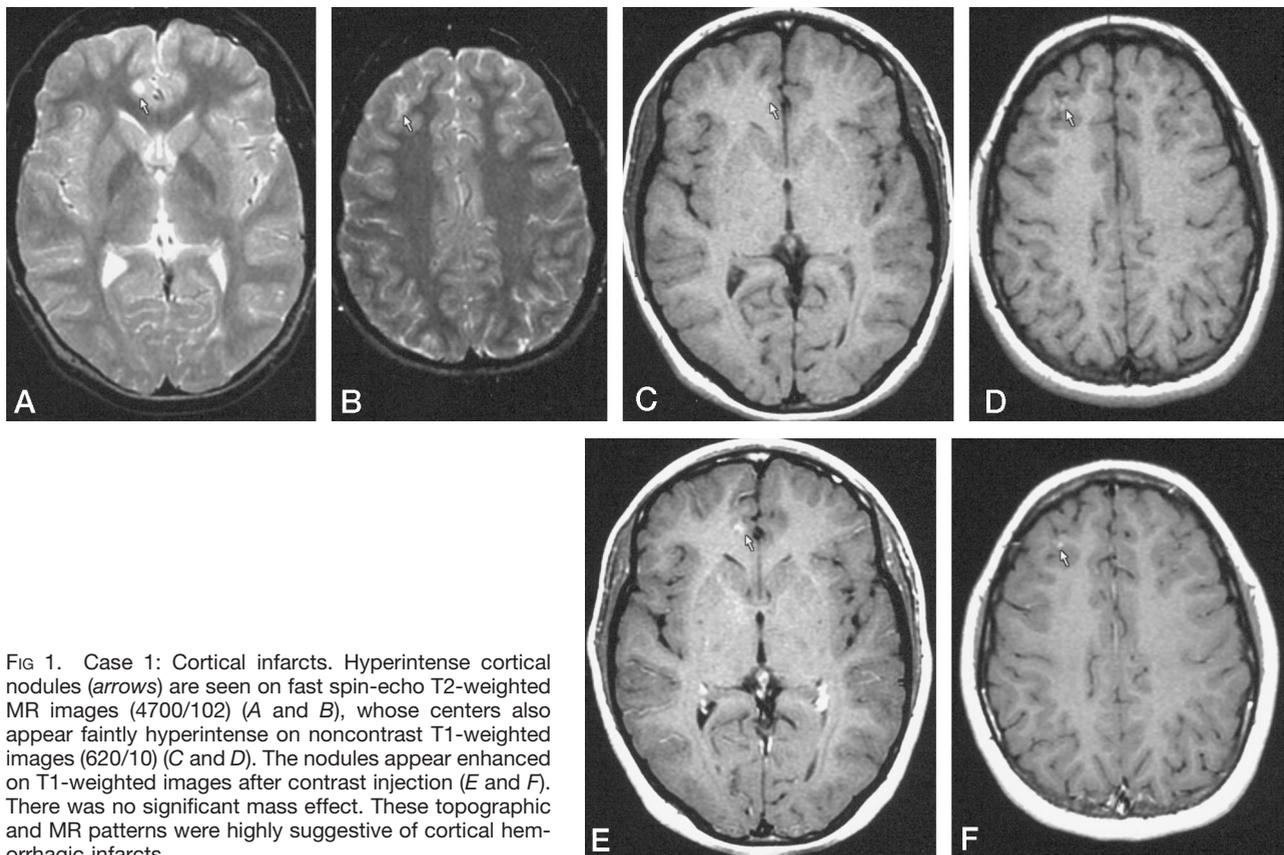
Case 1: Cortical infarcts. Hyperintense cortical nodules (arrows) are seen on fast spin-echo T2-weighted MR images (4700/102) (A and B), whose centers also appear faintly hyperintense on noncontrast T1-weighted images (620/10) (C and D). The nodules appear enhanced on T1-weighted images after contrast injection (E and F). There was no significant mass effect. These topographic and MR patterns were highly suggestive of cortical hemorrhagic infarcts.
